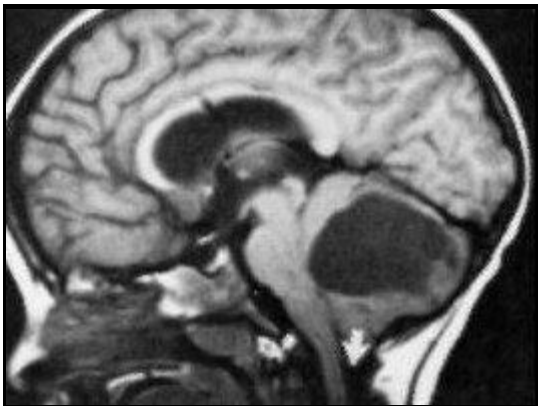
MRI image showing cerebellar pilocytic astrocytoma
